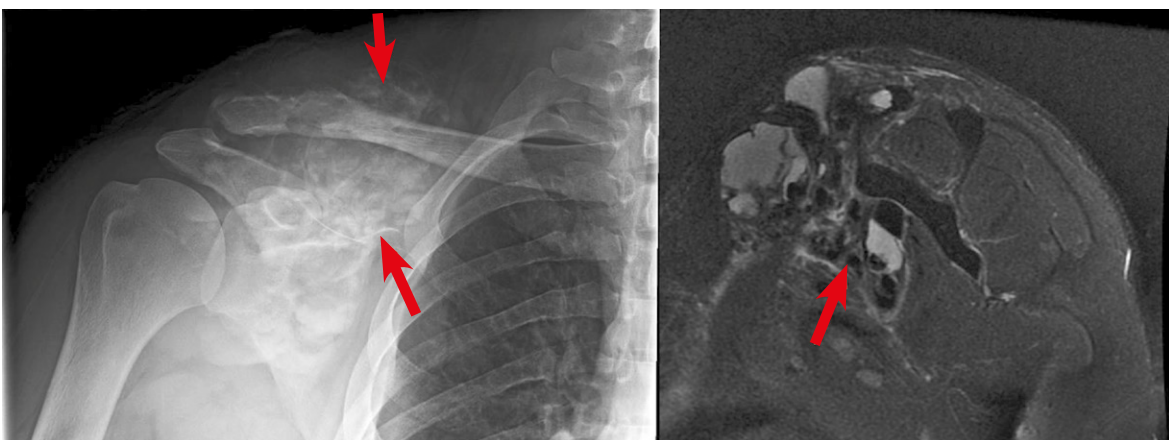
X-ray of the (left- 2 red arrows) shoulder show opacified cystic, lobulated peri-articular lesions in Tumoral Calcinosis. Coronal MRI T2 sequencing (right-red arrow) reveals hypointense lesions with septal enhancement, hyperintense fluid filled cavities and fluid-fluid levels consistent with sedimentation.
